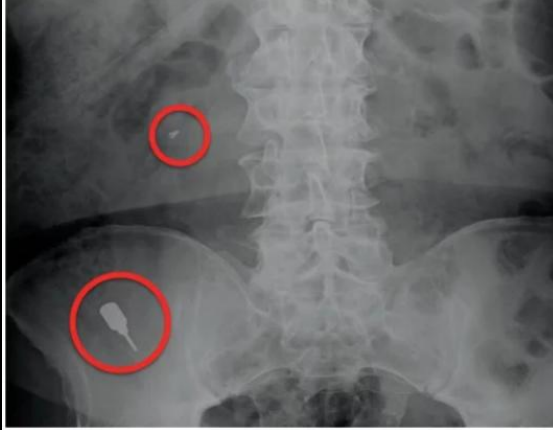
(left): Chest radiograph showing ingested cover screw into the duodenum and implant driver into the terminal ileum; Figure 3 (right): Throat pack — 4 x 4 is placed posterior to the area of treatment to provide a barrier from foreign body loss
